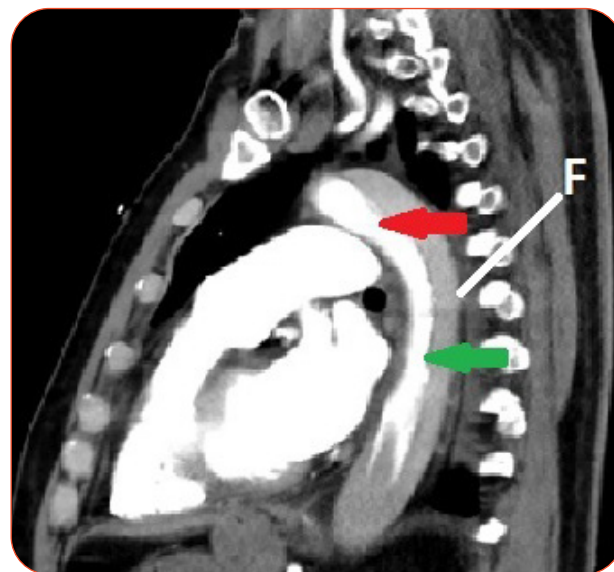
Sagittal CT view of the chest demonstrating the descending aortic dissection: red arrow = true lumen; F = false lumen; green arrow = dissection descending aorta.
